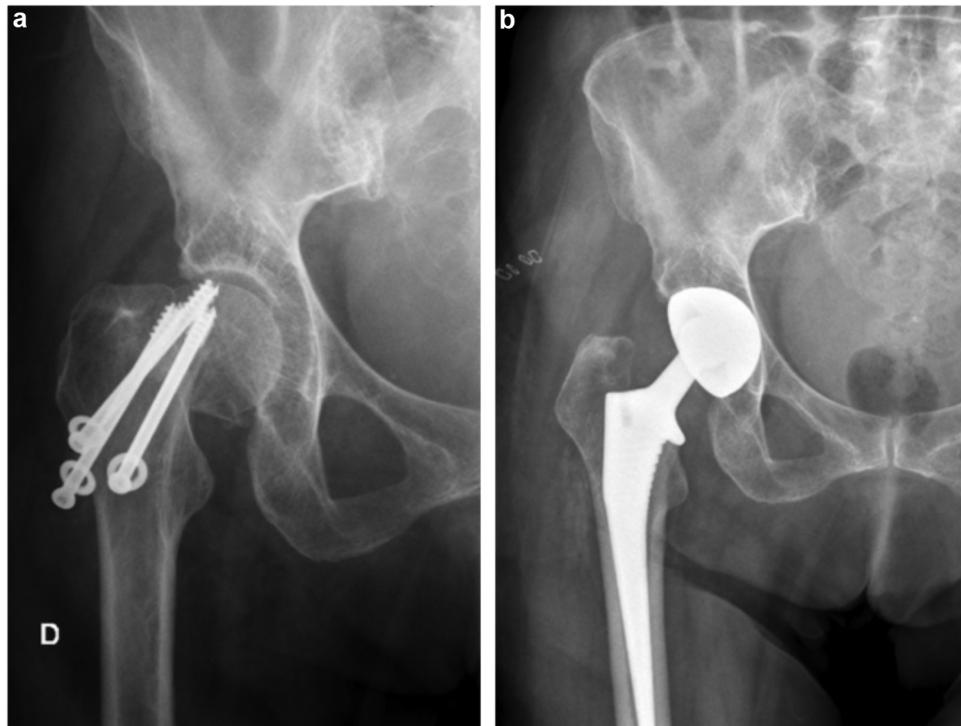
a: failure of internal fixation of a right femoral neck fracture; b: X-rays at 4 years' after the surgical revision by THA with DM cup (right leg).
